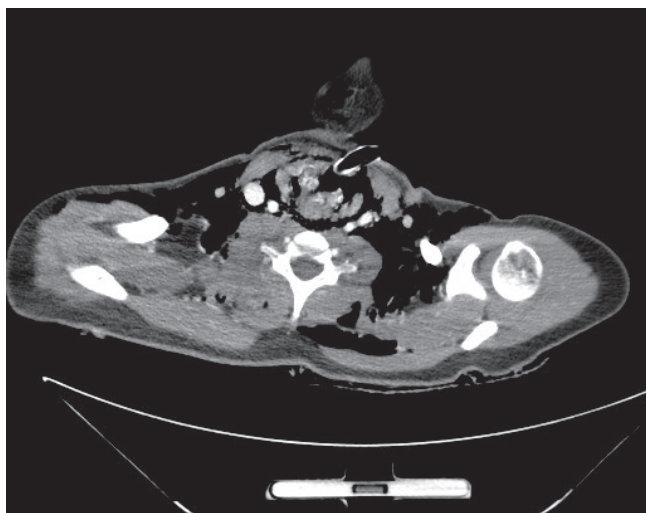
CT of the neck showing the entry point of the endotracheal tube
